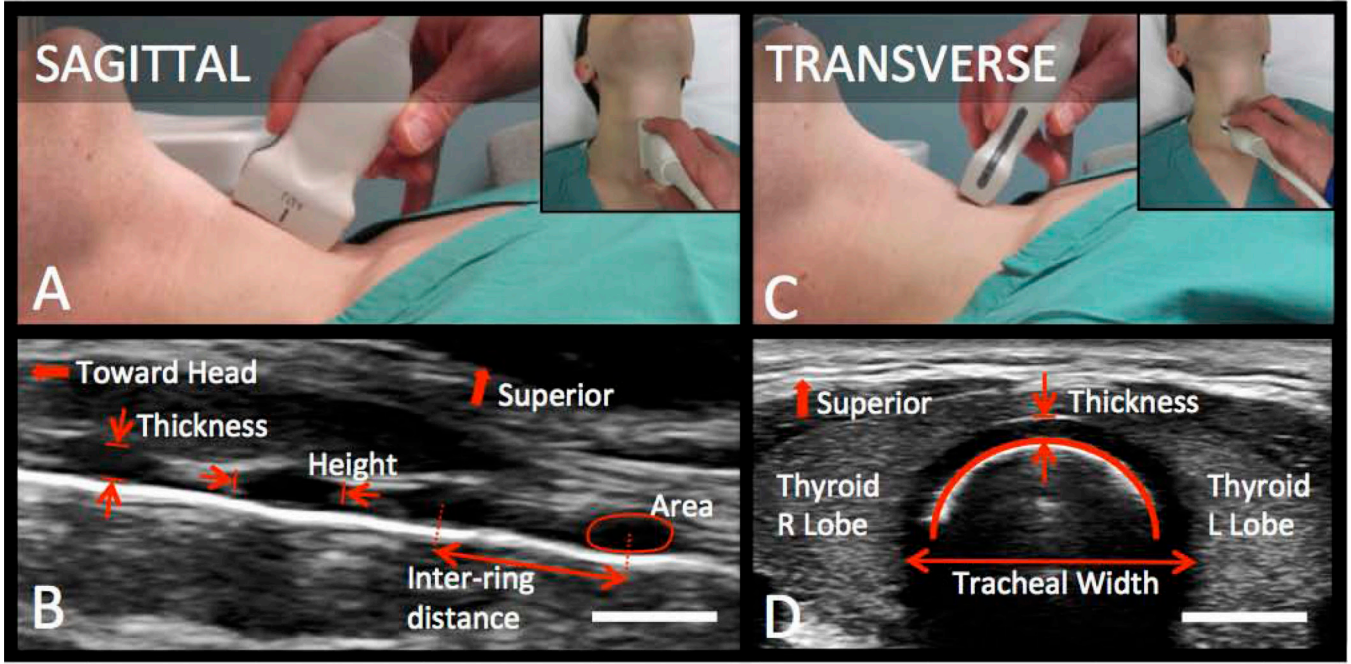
Ultrasound of the tracheal cartilage rings using a linear transducer
